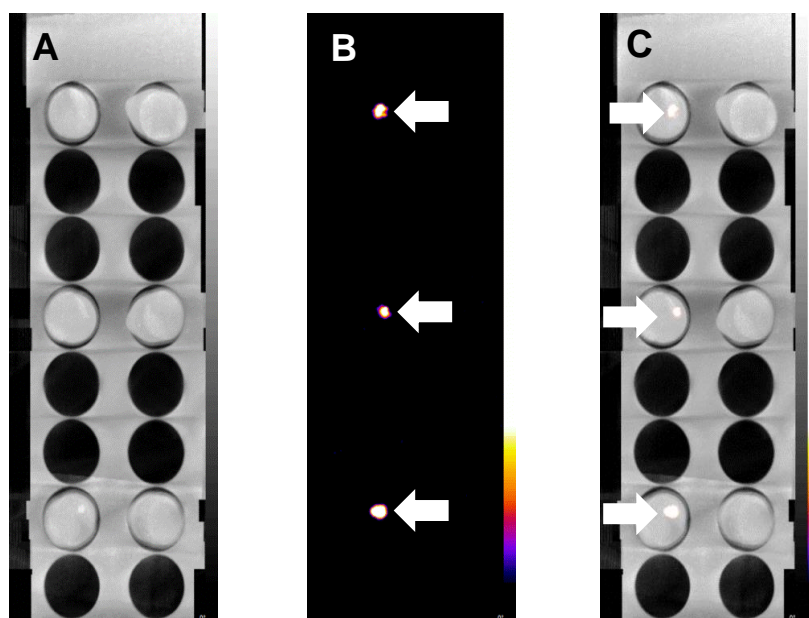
In situ* studies were performed by adding radiotracers in flasks of VSMCs maintained in normal (control) and high Ca/Pi medium. The ABs from these cells were then isolated by centrifugation and collected in eppendorf tubes. The eppendorf tubes were scanned on a nano SPECT scanner. MIP images of the scanned tubes (A) CT, (B) SPECT and (C) SPECT-CT. The ABs were incubated with radiolabeled bone seeking agent (^{99m}Tc -DPA Ale). The arrows show the uptake of radiotracers only in the pallet of the tubes containing ABs isolated from VSMCs maintained in a high Ca/Pi medium.
